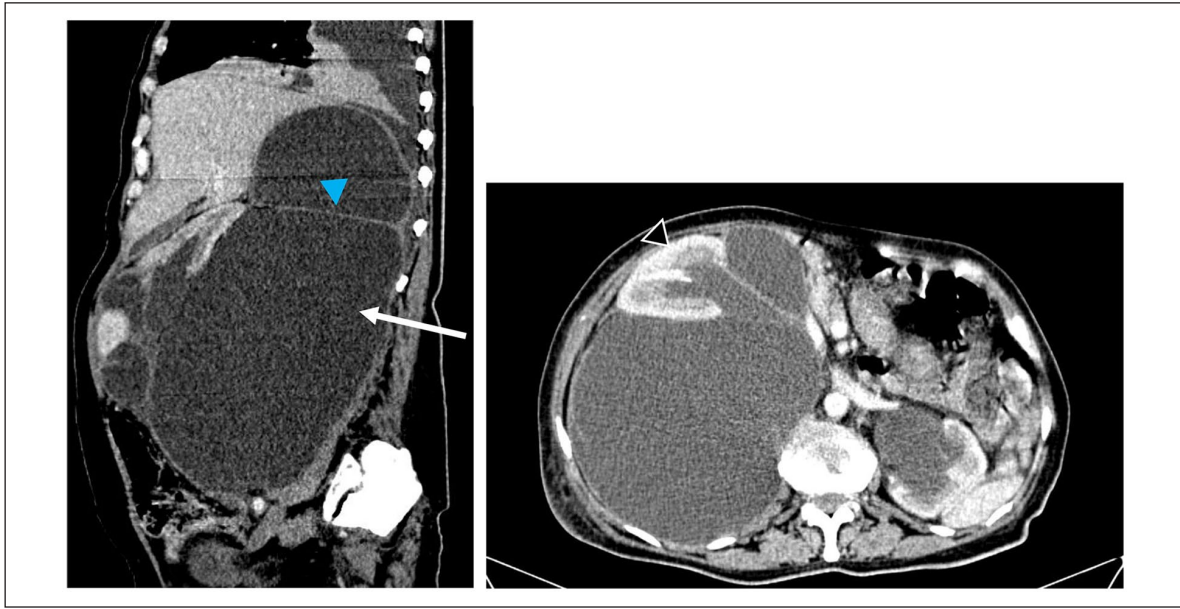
Sagittal and axial abdominopelvic computed tomography-scan in parenchymal phase: Pure liquid retroperitoneal mass (arrow) pushing the kidney against the anterior abdominal wall (black arrowhead). Note the well-defined thin septa (blue arrowhead).
